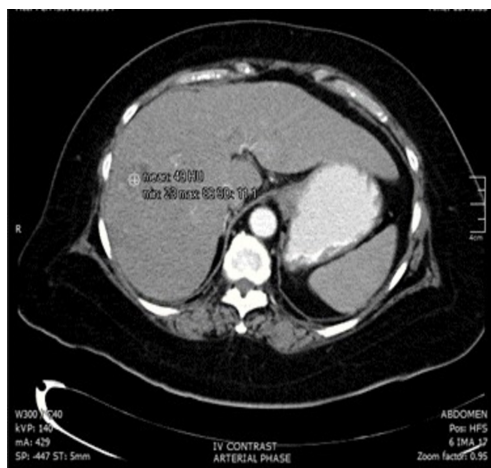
Region of interest (ROI) was drawn on the clearly demonstrated portion of the liver lesion in the CT image
